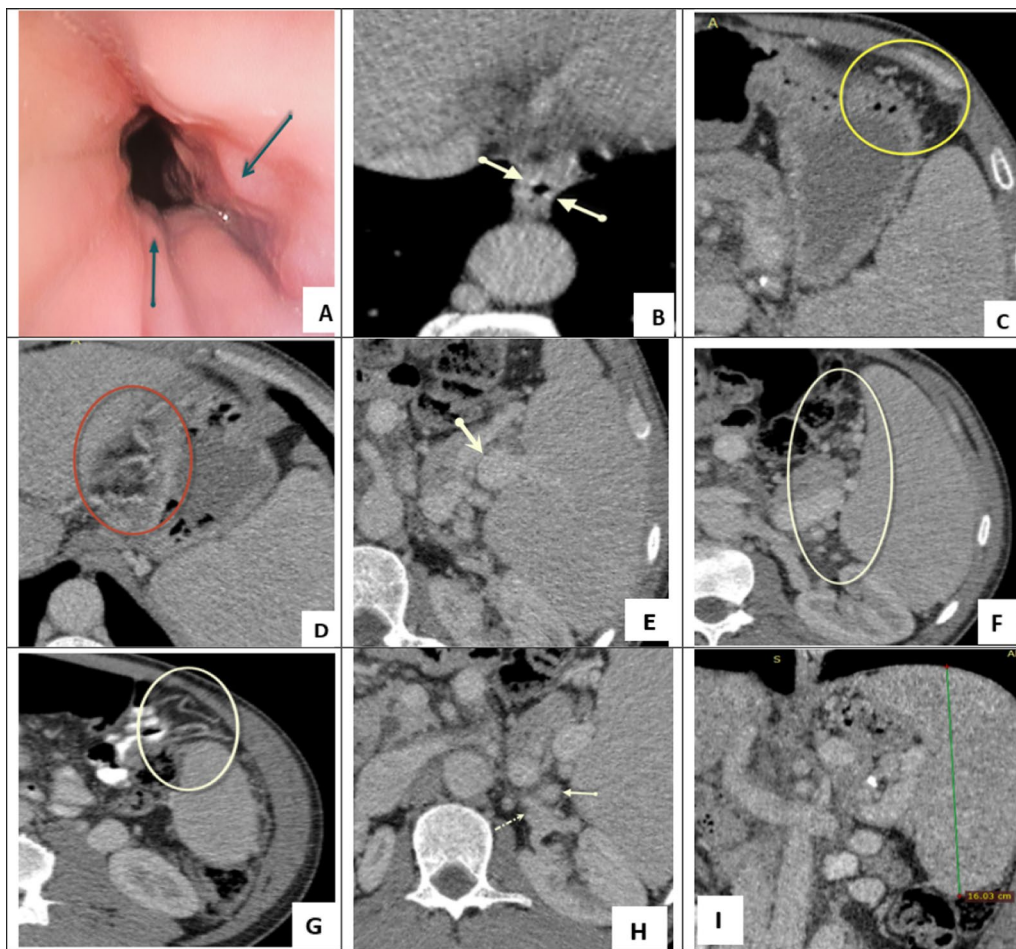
A 55-year-old male patient with chronic liver disease and esophageal varices: A Upper GI endoscopy reveals 2 cords grade I (solid arrows). Axial CT shows the following; B 2 cords grade I (solid arrows), C, D Retrogastric (adventitial varices), E dilated and tortuous splenic vein (solid arrow), F hilar splenic varices (oval region). G Lower pole perisplenic varices (oval region). H Lienorenal shunt (solid arrow), left renal vein (dashed arrow). I Coronal CT demonstrates mild enlargement of the LS diameter of the spleen to 16 cm
